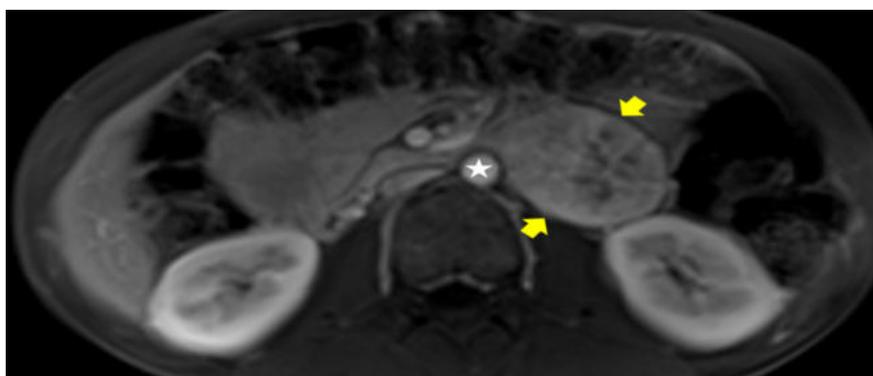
In contrast-enhanced abdominal magnetic resonance imaging, a well-circumscribed mass lesion with homogeneous contrast, adjacent to the left kidney lower pole, has the widest anterior-posterior diameter 40 mm, the widest mediolateral diameter 50 mm, and the widest craniocaudal length 60 mm.
